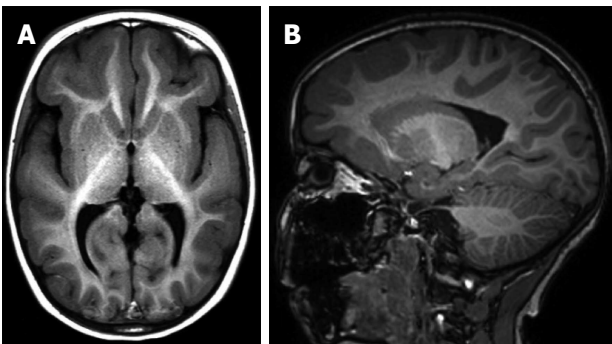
A 5-year-old girl with incomplete lissencephaly. Axial T1-weighted (A) and sagittal 3D T1-weighted (B) magnetic resonance images show pachygyria in frontotemporal region.
